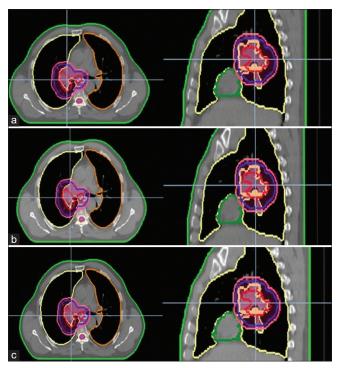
Representation of the 95% dose distribution obtained with plans based on the extrapolated Hounsfield units-relative electron density calibration curve for Siemens, GE and Toshiba computed tomographies in transverse and coronal slices. (a) Siemens Somatom, (b) GE Optima, (c) Toshiba Aquilion
